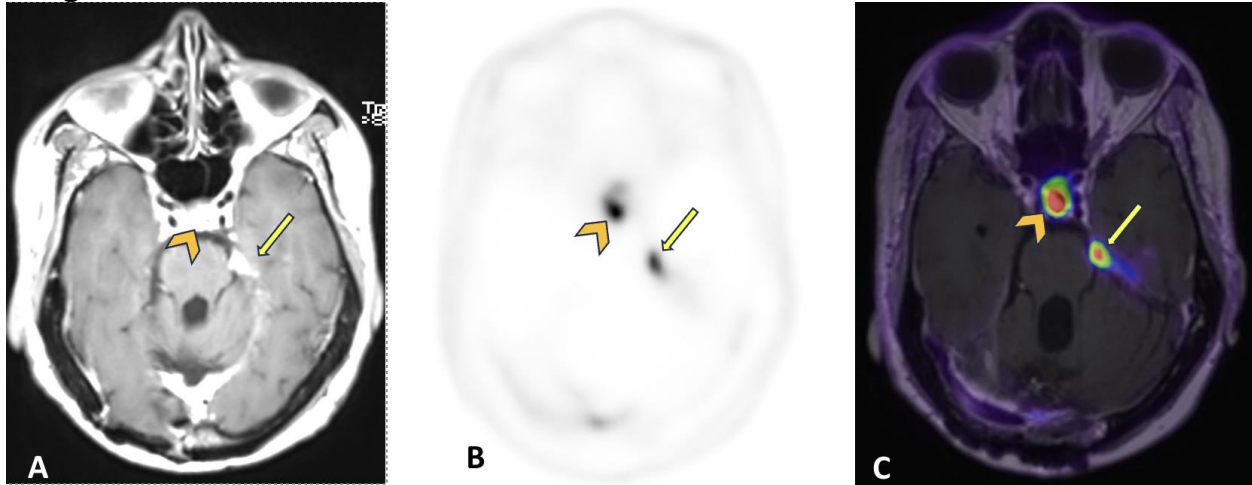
Dural-based nodular enhancement along the left tentorium visualized on axial postcontrast T1 image (A) demonstrates intense DOTATATE avidity with SUV up to 16.0 on PET (B) and PET/MRI fused (C) images represented by arrows. Arrowhead representing physiologic DOTATATE avidity in the pituitary gland.
